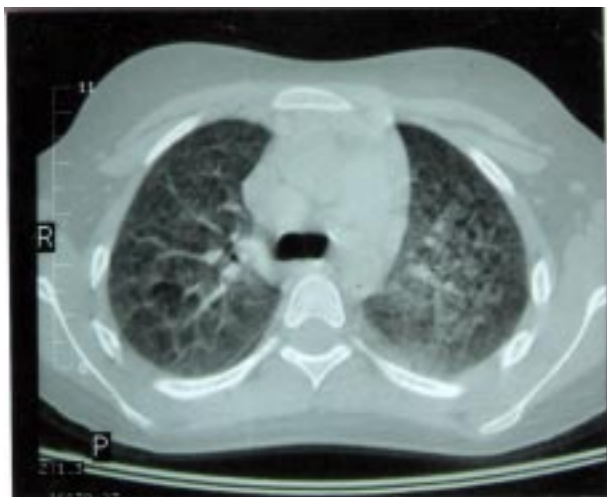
CT thorax showing bilateral diffuse ground glass attenuation and patches of consolidation with early fibrotic changes.
